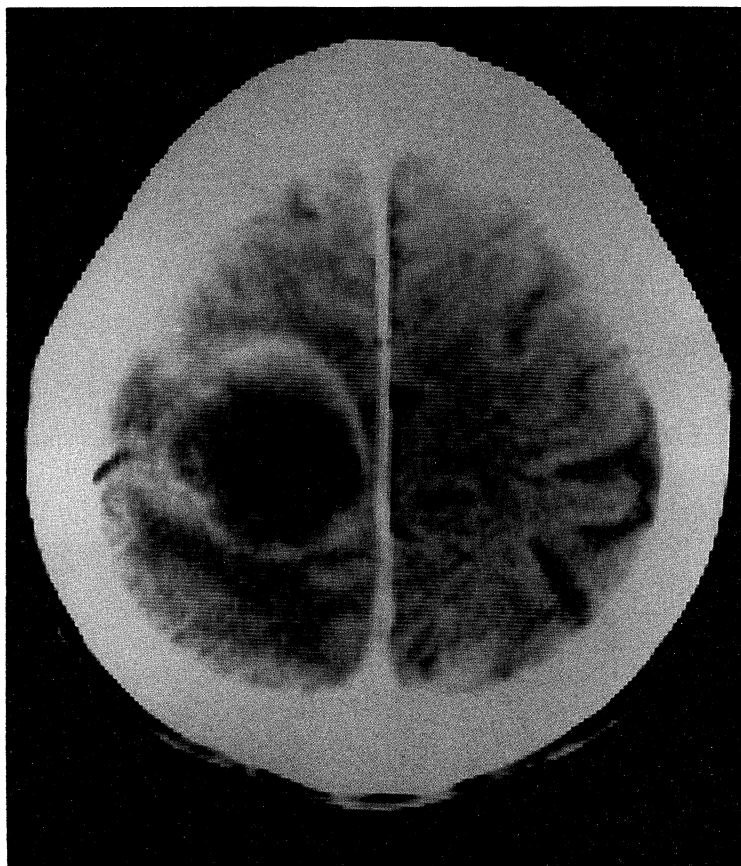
A brain CT-scan on June 3
